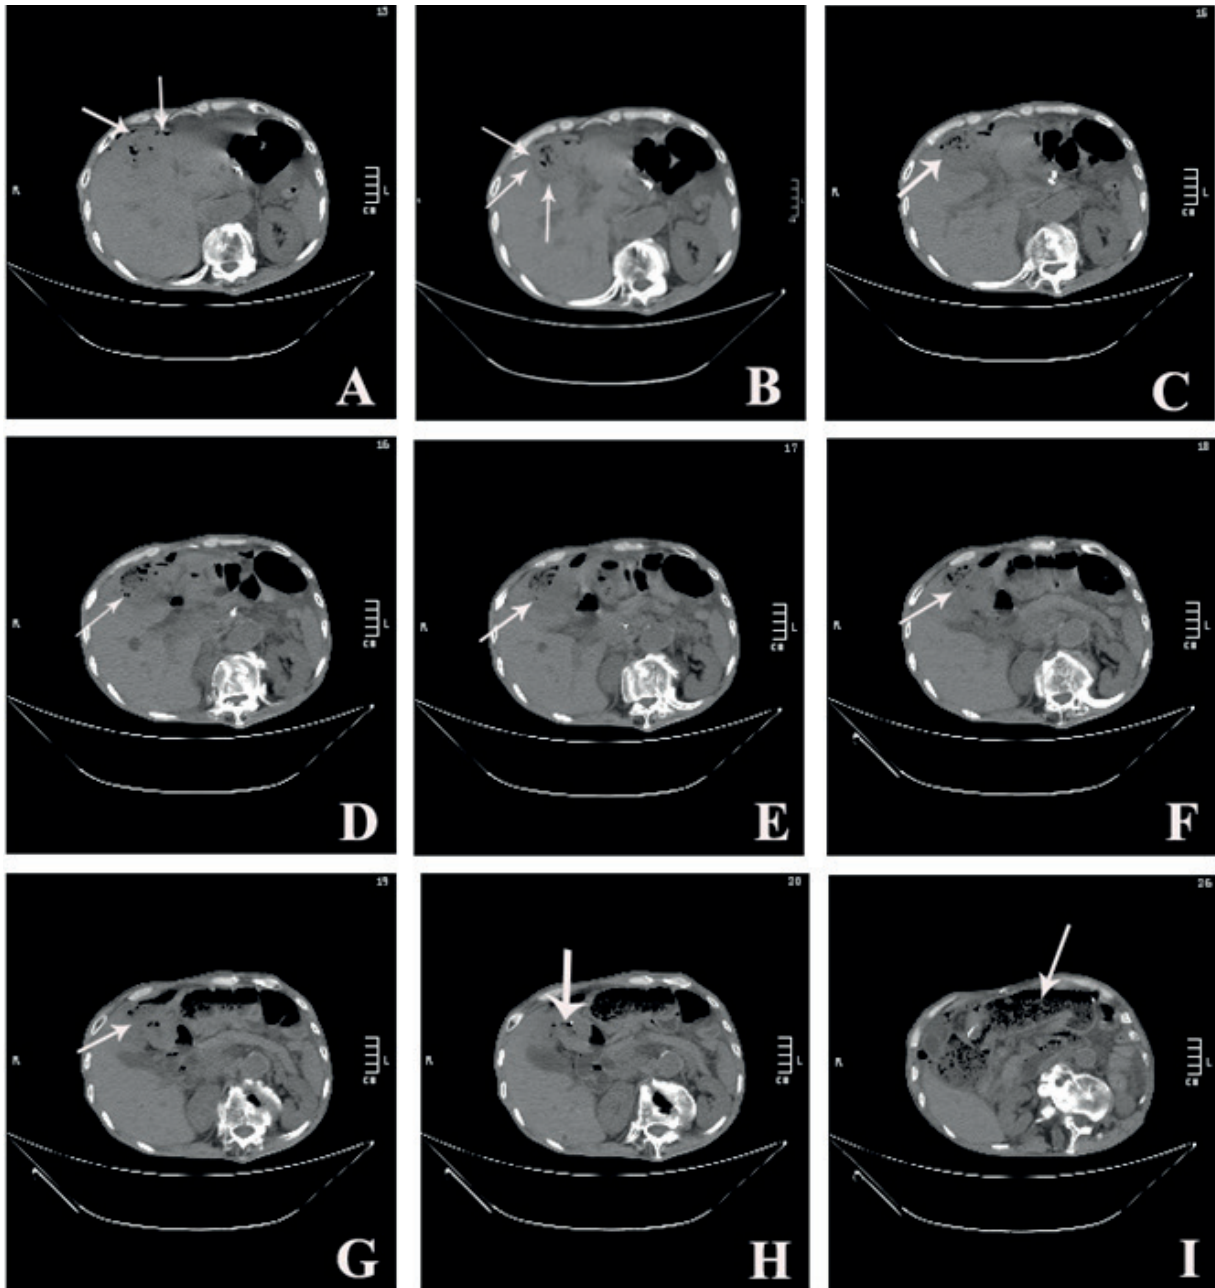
Preoperative imaging studies with abdominal computed tomography (CT) scan. *A*, Subdiaphragmatic free air (*white arrows*); *B-G*, Successive slice images showing the liver cystic mass (*white arrows*); *H*, Hepatogastric fistula formation (*white arrow*); *I*, Distension of interposed jejunum (*white arrow*).
